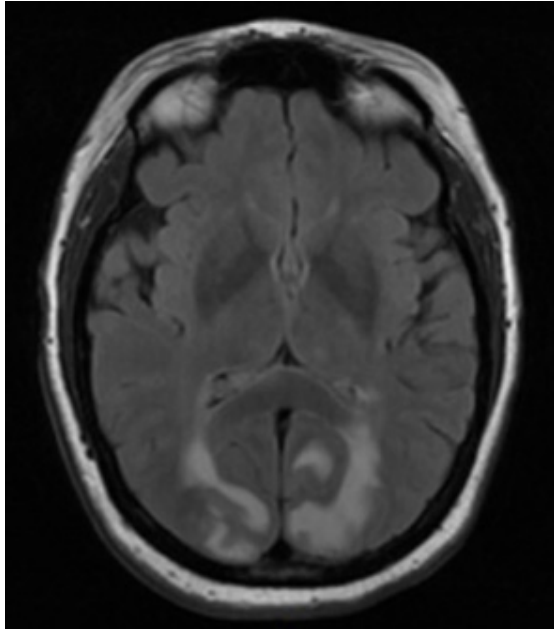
The T2 FLAIR of the brain shows fairly symmetric subcortical area in a posterior predominant pattern including parietal lobes.
